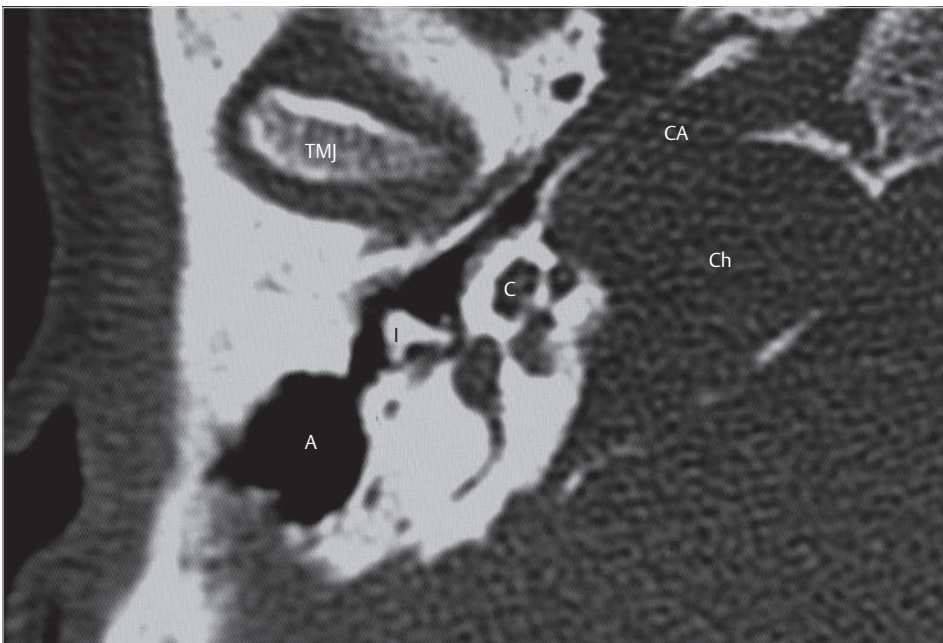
This 32-year-old woman presented with right draining ear with profound mixed deafness after two tympanoplasties elsewhere. The axial CT shows presence of soft tissue density in the petrous apex eroding the cochlea. A molded incus was used as a columella in the former surgery. The apical region is isolated from the aerated space in the middle ear. A, antrum; C, cochlea; CA, carotid artery; Ch, cholesteatoma; I, incus columella; TMJ, temporomandibular joint.
